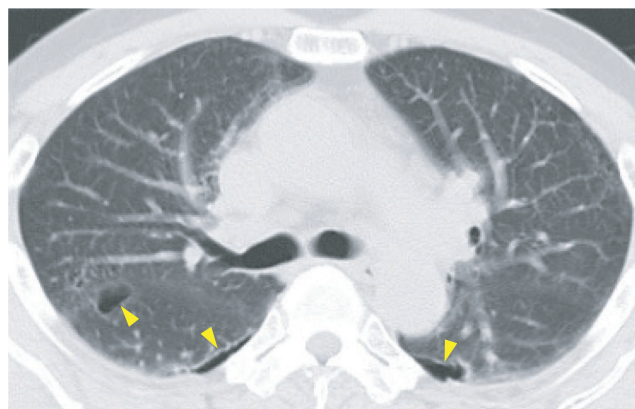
Computed tomography (CT) without contrast media exhibited small air leakages on the backside of the upper lung lobe (arrowhead)
